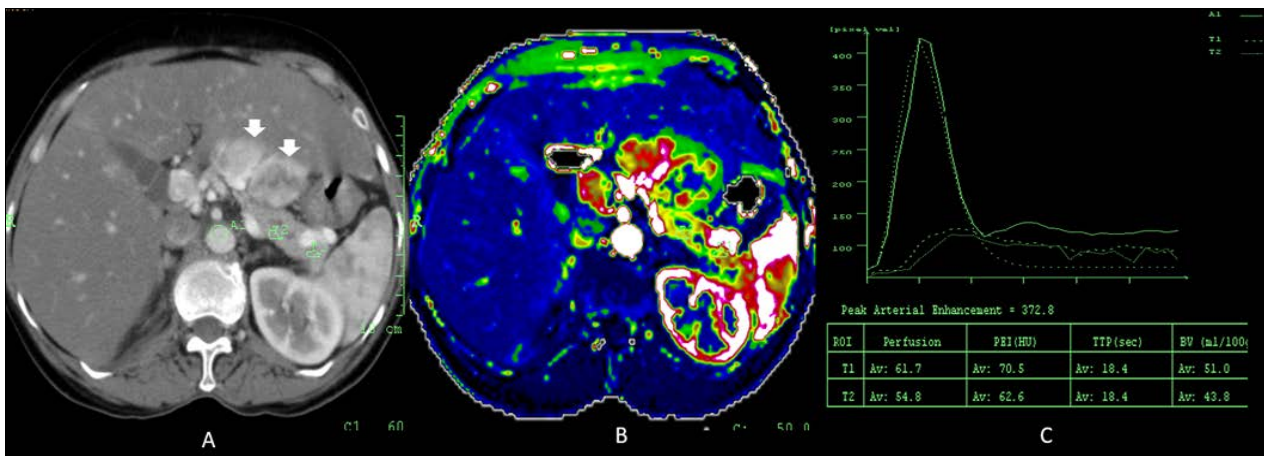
Perfusion CT image shows a hyper enhancing mass in the proximal body of pancreas (white arrows in A). CT perfusion color map of blood flow (B) shows mass showing a distinct range of colors compared with the normal pancreatic parenchyma (b). ROI's are placed in the aorta (A1) and within the normal tail (T2) and distal body (T1) of pancreas with their corresponding enhancement curves and perfusion parameters table shown in image C.
